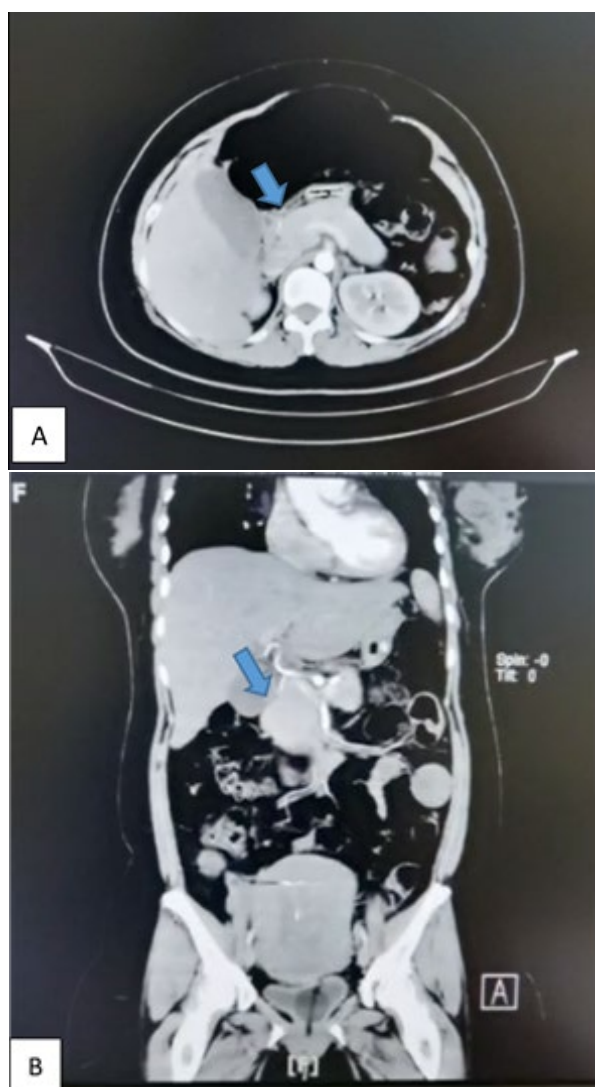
Abdominal CT scan image showing acute pancreatitis.
